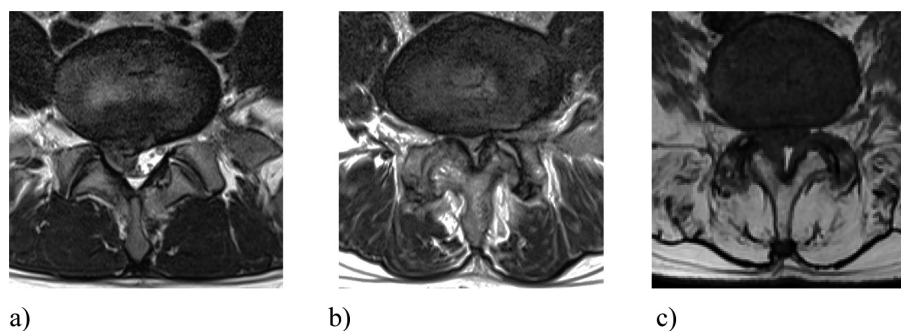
The grading method of L4/5 fat infiltration on T2-weighted magnetic resonance imaging used in this study of 225 patients with degenerative lumbar spine disease: Fat infiltration rated as a) Grade 0 in the absence of fatty degeneration (0–10%); b) Grade 1 in the case of slight fat infiltration (10–50%); and c) Grade 2 in the case of severe fat infiltration (>50%).
